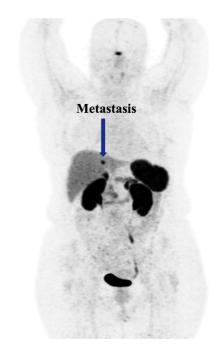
The PET-CT scan with 68Ga-DOTATATE detect the Metastasis of NET
